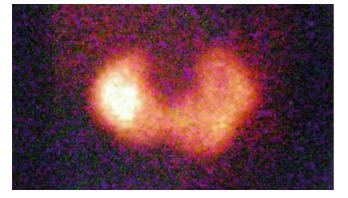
Anterior view of DMSA scintigraphy in a baby with horseshoe kidney
